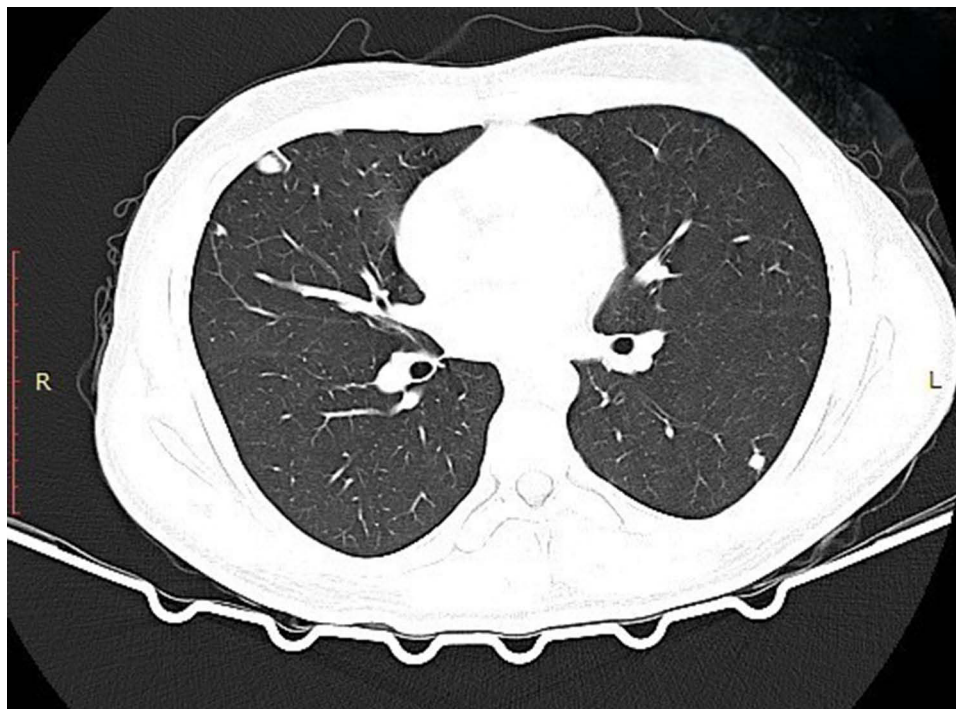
Axial chest computed tomography (lung window) at presentation showing multiple, well-defined bilateral pulmonary nodules consistent with metastatic disease.
